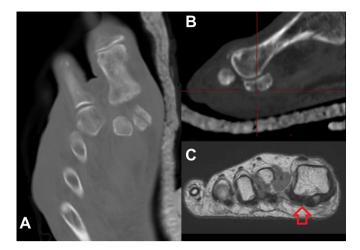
Computed tomography shows fracture of sesamoid bone: (A) transverse view; (B) sagittal view. (C) Avascular necrosis of lateral sesamoid: small and dark looking lateral sesamoid compared to the medial one on magnetic resonance imaging photon density sequence.
